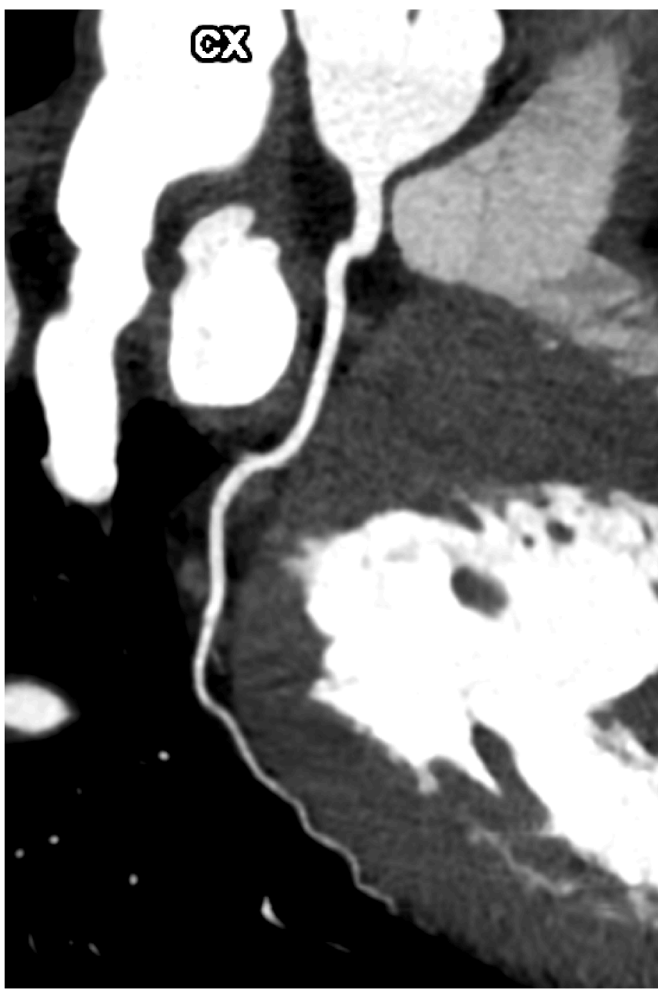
Computed tomography scan of the ramus circumflexus of the left coronary artery.
